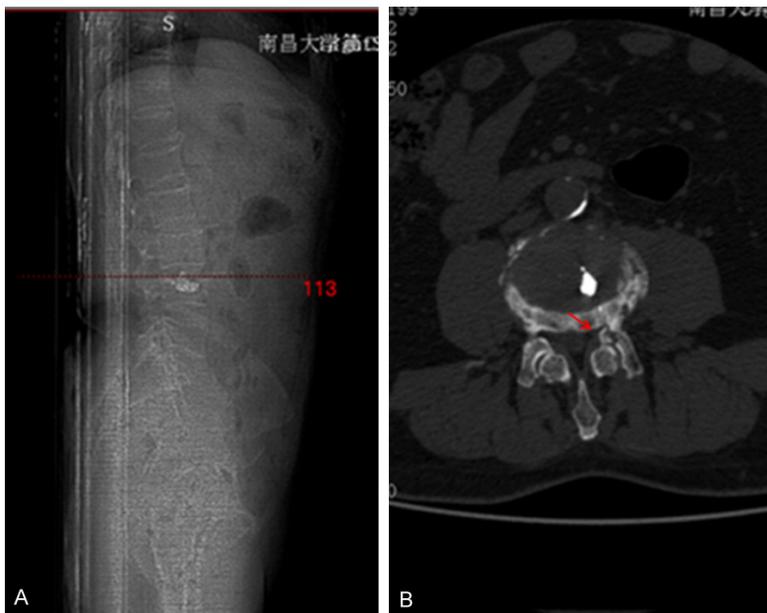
CT detected traveling nerve root of L4 (red arrow) was compressed due to the fracture of superior articular process of L4. A. Locator; B. Coronal CT.
